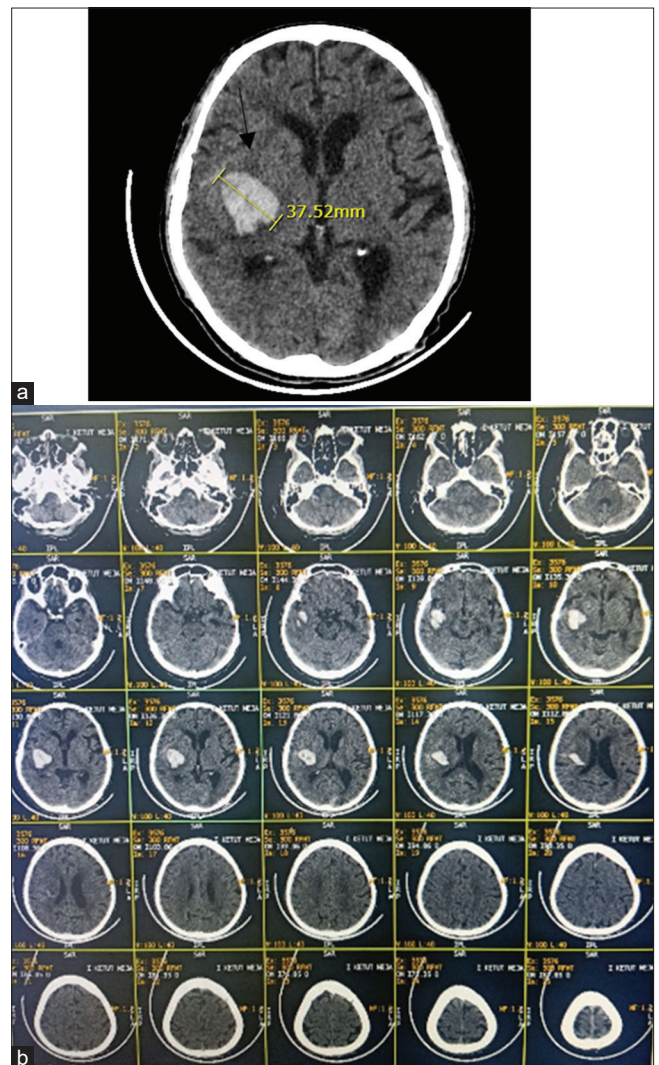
(a and b) Picture of computed tomography scan of the brain without contrast, showing a picture of bleeding in the right basal ganglia area with a blood volume of about 21.9 ml, with pericerebral edema of the right lateral ventricle, as well as anterior and posterior horns
